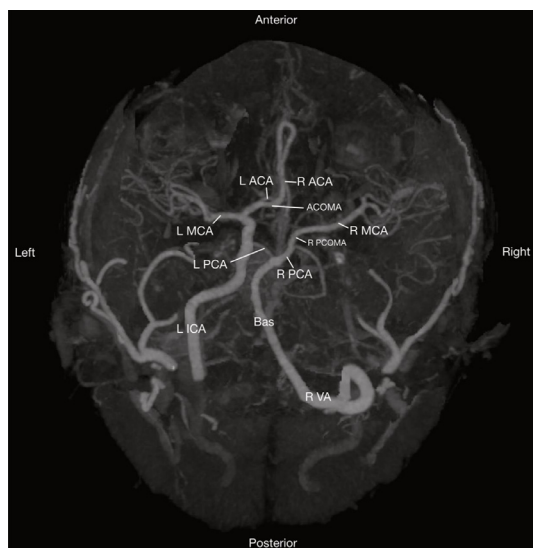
CT angiography 3D maximum intensity projection of Circle of Willis vessels. A dorsal/cranial view of the brain is shown (anterior at the top of the figure, posterior at the bottom of the figure). L ICA = left internal carotid artery, R VA = right vertebral artery, Bas = basilar artery, R PCA = right posterior cerebral artery, L PCA = left posterior cerebral artery, L MCA = left middle cerebral artery, R MCA = right middle cerebral artery, R PCOMA = right posterior communicating artery, ACOMA = anterior communicating artery, L ACA = left anterior cerebral artery, R ACA = right anterior cerebral artery.
